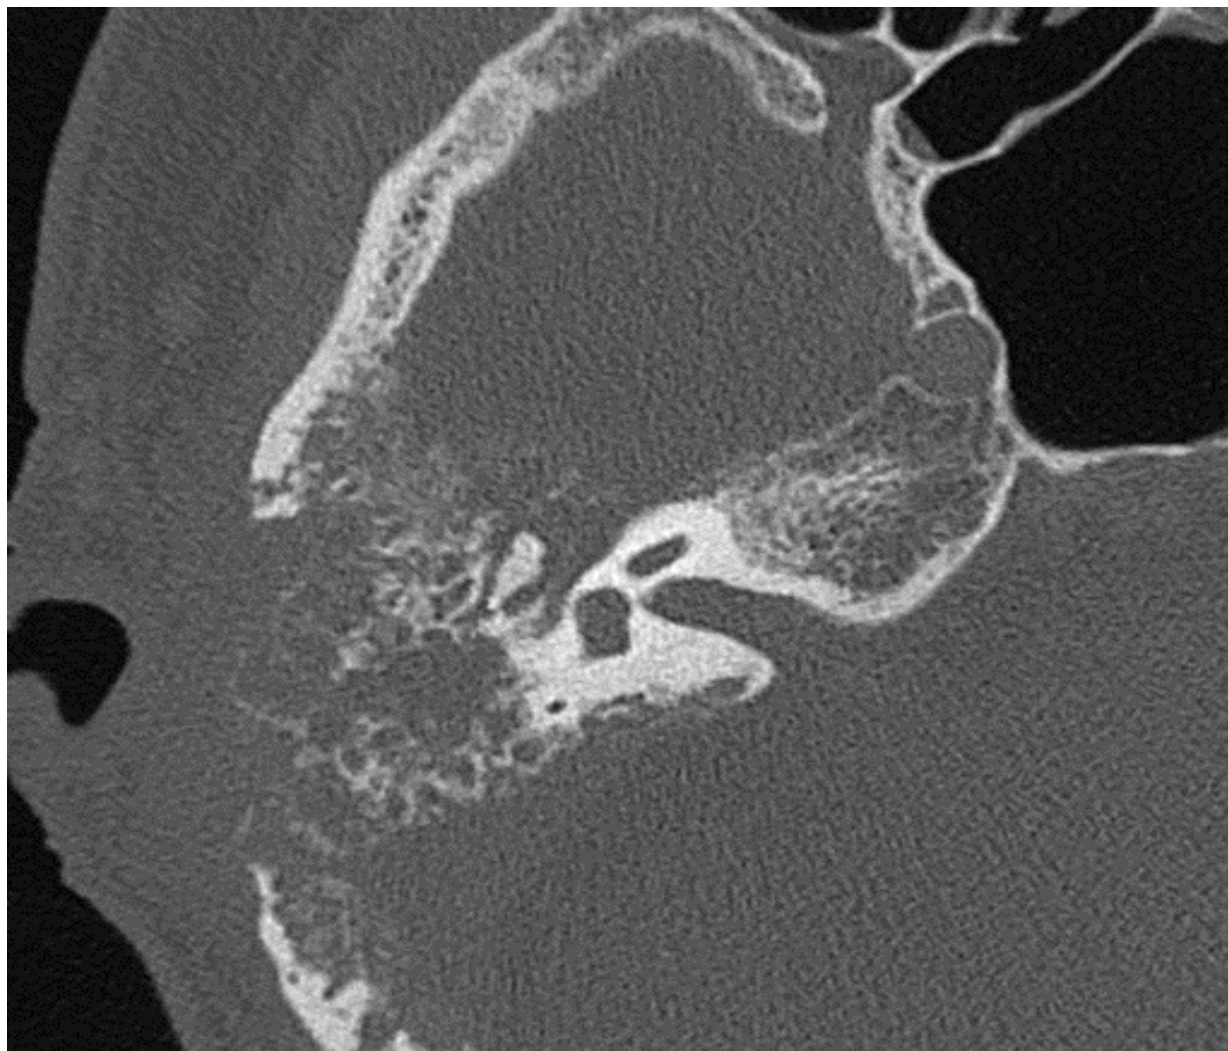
Axial CT Scan of the right temporal bone ear showing tumor recurrence of the middle ear and mastoid.
